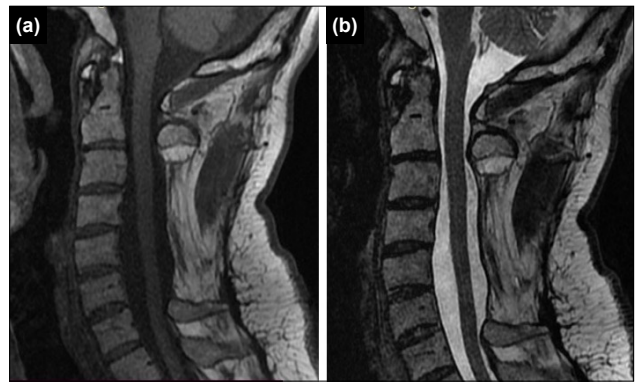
(a) Postoperative six-month T1-weighted magnetic resonance imaging (MRI). (b) Postoperative six-month T2-weighted MRI.
